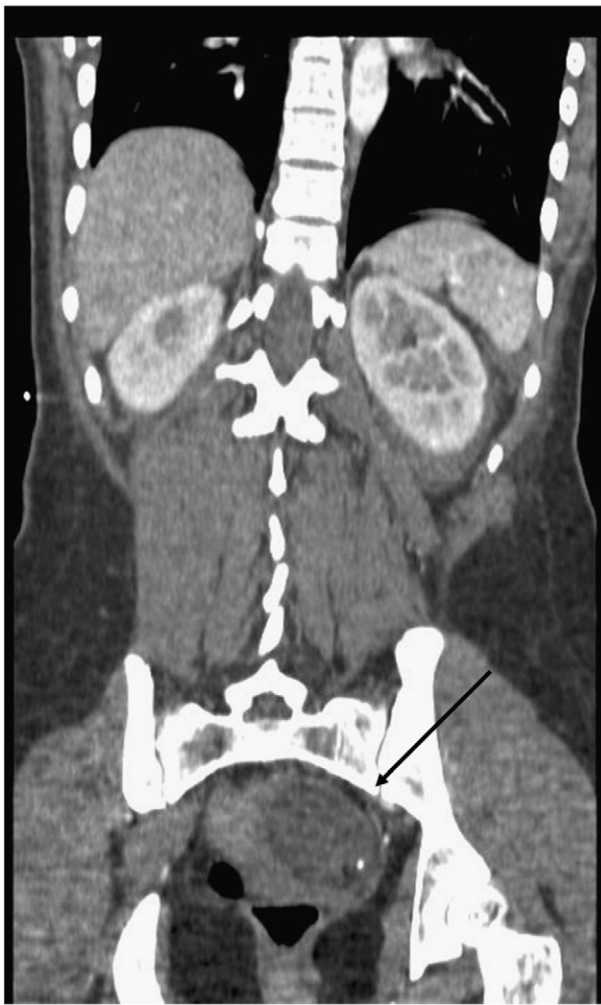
A coronal reconstruction of a CT scan of the patient's abdomen and pelvis reveals a cystic left adnexal mass with an internal focus of fat and high attenuation material suggesting an ovarian teratoma (black arrow).
